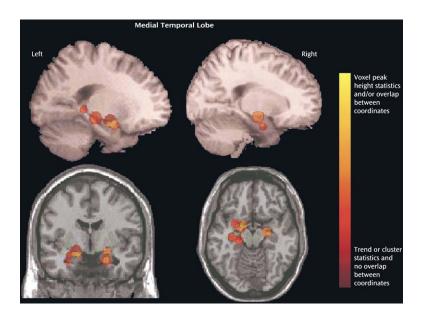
Structural Abnormalities Identified by MRI Scan in Schizophrenia
